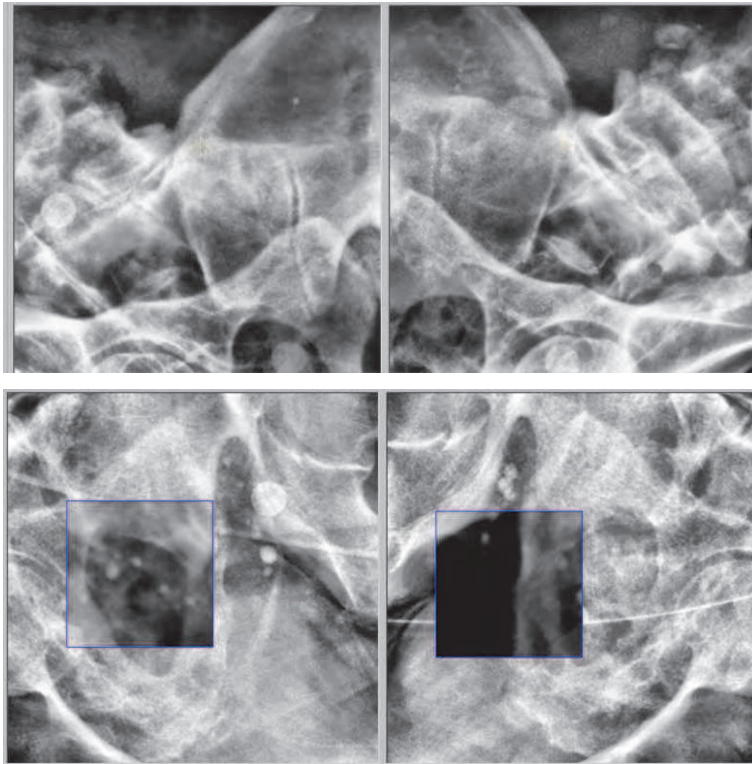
The patient localization by ETX system. Superior figure shows the snapshot of 2D oblique X-ray images. Inferior figure shows the comparison of X-ray image (outer-ROI) and DRR (inter-ROI).
